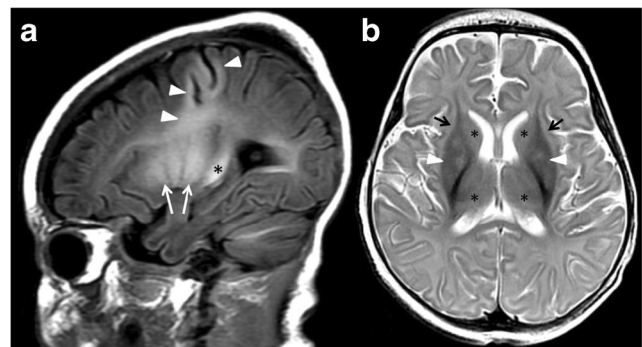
Day 7 status post-cardiac arrest in a 3-month-old child. The sagittal T1-weighted image shows hyperintensity in the motor cortex and cortical-spinal tracts (a, arrowheads), putamen (a, white arrows), and optic radiations (a, black asterisk); the axial T2-weighted image shows mixed hyperintense-to-hypointense signal changes in the putamen and globus pallidus (b, white arrowheads) and hyperintensity in the caudate and thalamus, respectively (b, black asterisks) and hyperintensity in the external capsules (b, black arrows)
